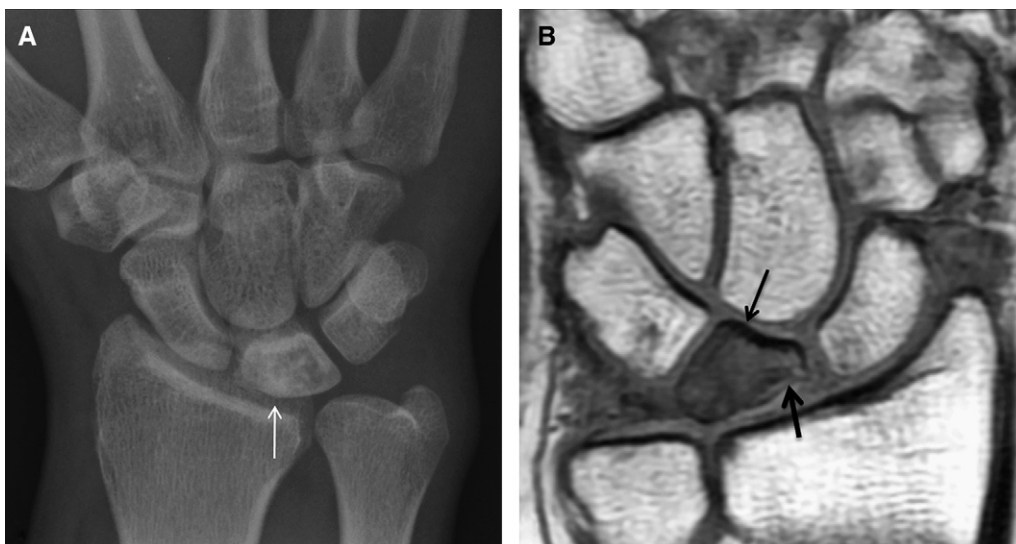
Kienböck disease. Anteroposterior radiograph (A), demonstrating sclerosis of the lunate (white arrow), and, in a different patient, the coronal T1-weighted magnetic resonance image (B), showing diffuse low signal on T1 (thin black arrow) and flattening of the radial aspect of the lunate (thick black arrow).
